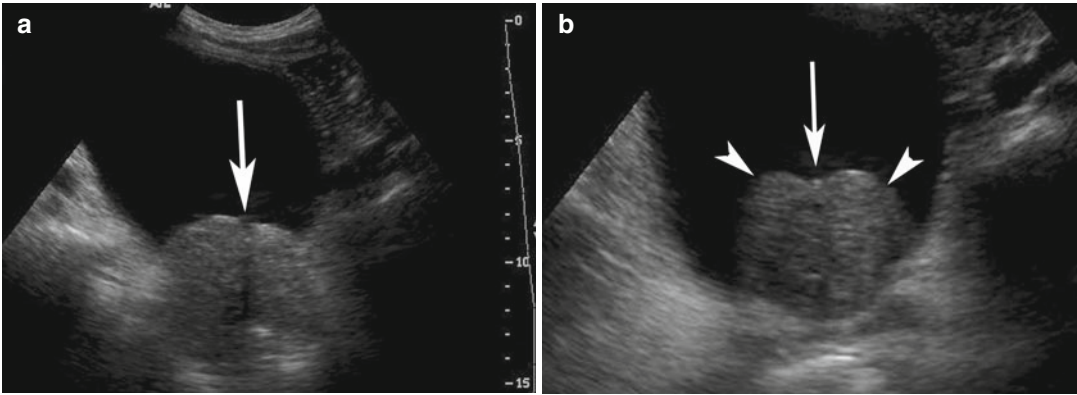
(a, b) Two ultrasound images of the bladder in a patient with suspected bladder mass. The mass is contiguous with the prostate and of same echogenicity (arrowheads). Centrally, the urethra is identified (arrow)
